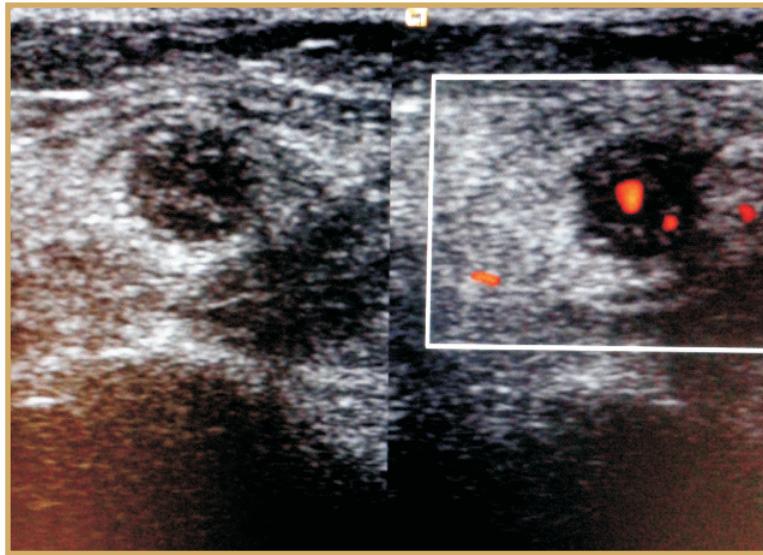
Thickened and inflamed Ulnar nerve showing rounded contour, hypoechoicity and increased vascular signals on Doppler (inset). CSA 0.14 sq.cm
